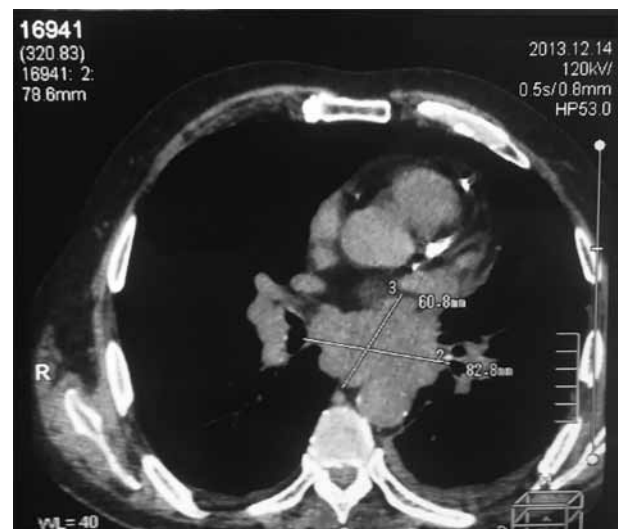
CT scan of the thorax: mediastinal lymphadenopathy.
